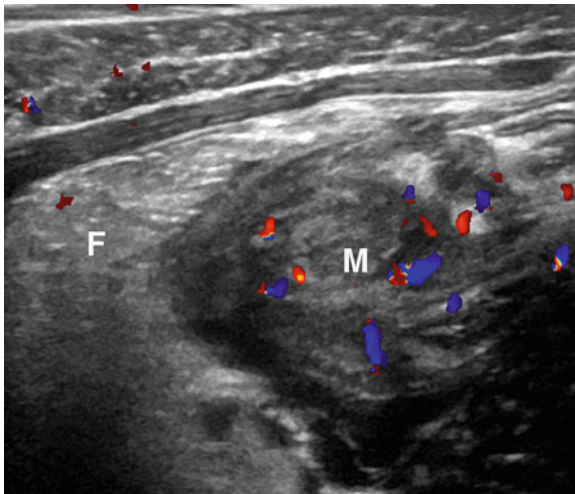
Periappendiceal phlegmon. Note indurated soft-tissue mass containing internal flow on transverse color-Doppler sonogram, surrounded by inflamed echogenic fat (“F”) in right lower quadrant. There was no liquefied pus for drainage
